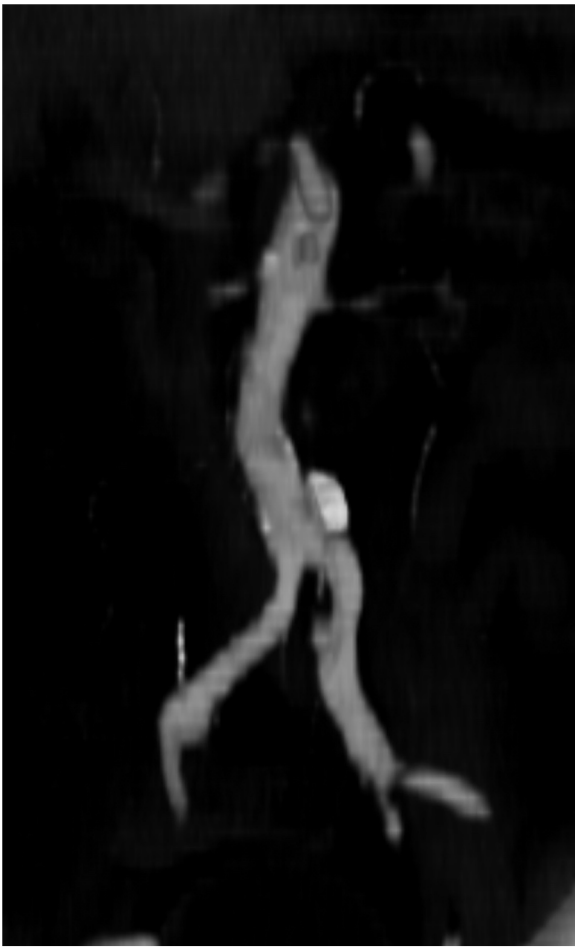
Preoperative CT-angiography showing significant atherosclerotic disease in correspondence of the infrarenal aortic segment and right renal artery.
